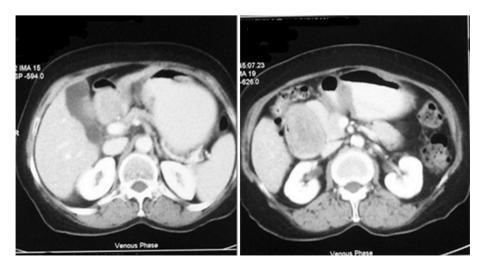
Computed tomography (CT) scan showing a soft-tissue mass extending into the pylorus.
